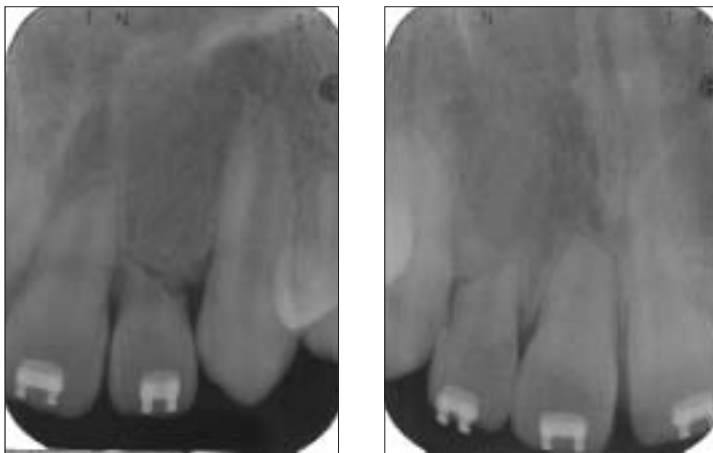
Follow-up periapical radiographs of cuspids.
